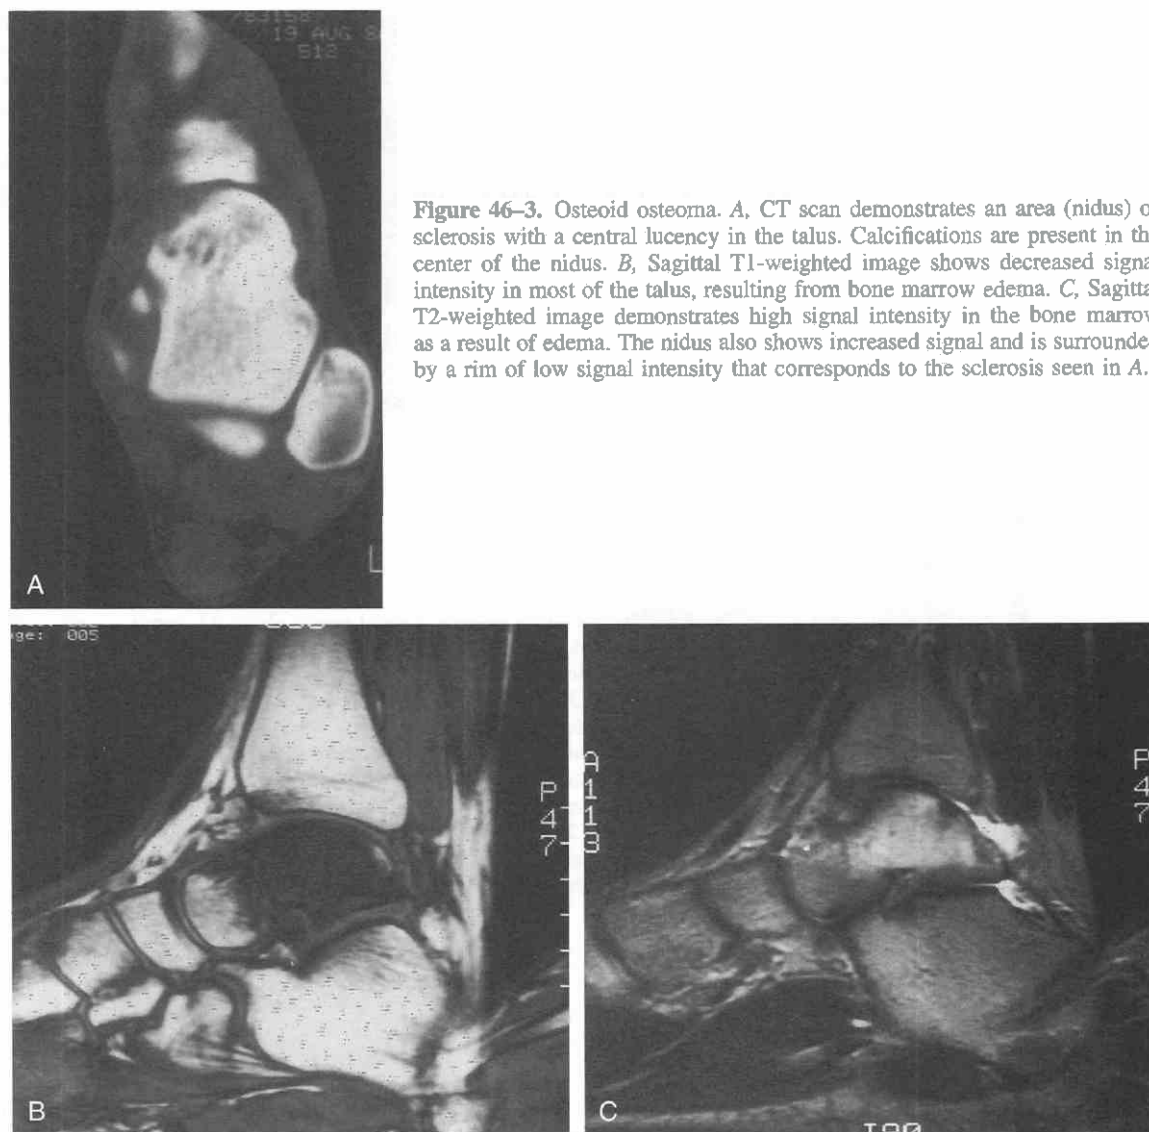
Osteoid osteoma. *A*, CT scan demonstrates an area (nidus) of sclerosis with a central lucency in the talus. Calcifications are present in the center of the nidus. *B*, Sagittal T1-weighted image shows decreased signal intensity in most of the talus, resulting from bone marrow edema. *C*, Sagittal T2-weighted image demonstrates high signal intensity in the bone marrow as a result of edema. The nidus also shows increased signal and is surrounded by a rim of low signal intensity that corresponds to the sclerosis seen in *A*.
